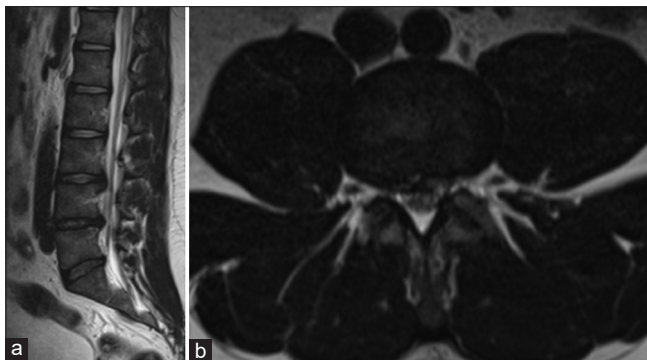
(a) Sagittal T2 weighted magnetic resonance imaging of the 30-year-old male showing mild disc bulge at L3-4 with mild compression of the nerve root on the right side (b) Axial T2 weighted magnetic resonance imaging of the 30-year-old male showing mild disc bulge at L3-4 with mild compression of the nerve root on the right side
